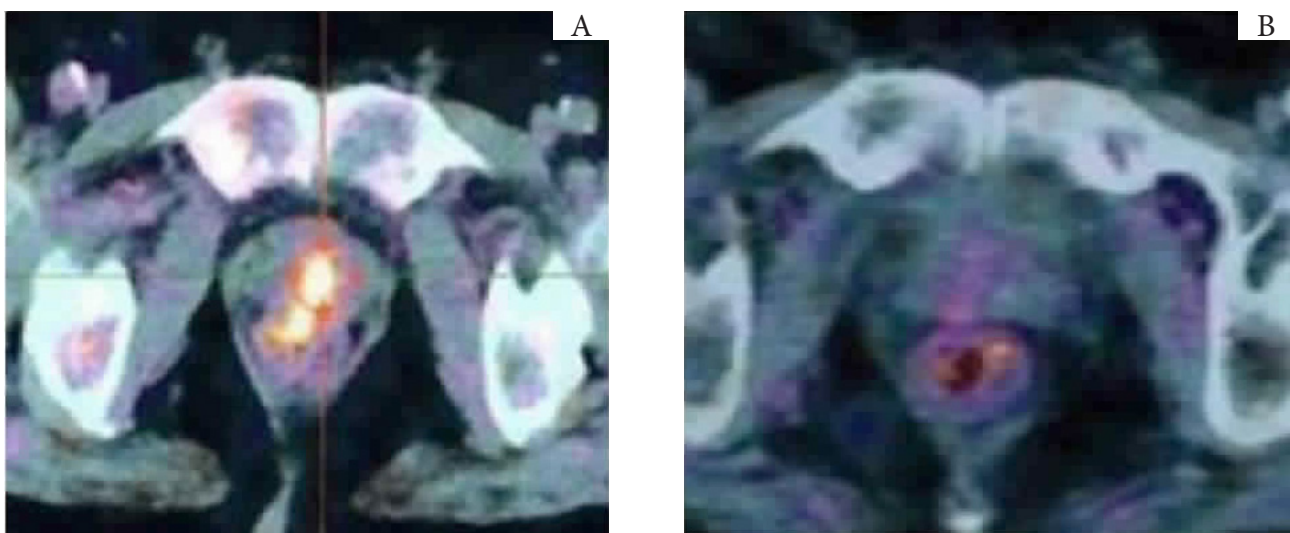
^{18}F -Choline-PET/CT at prostate level; (A) before radiotherapy and (B) after radiotherapy
